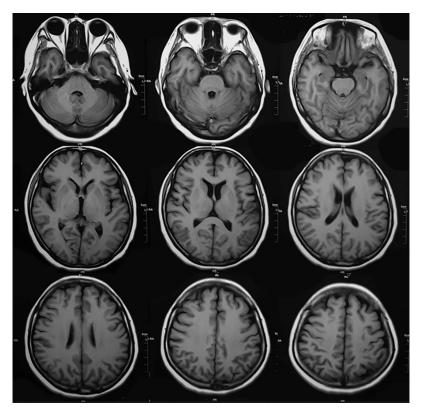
Traditional MR Imaging. Traditional MR imaging showed no evidence of a cerebral infarction. Single column fitting image.
